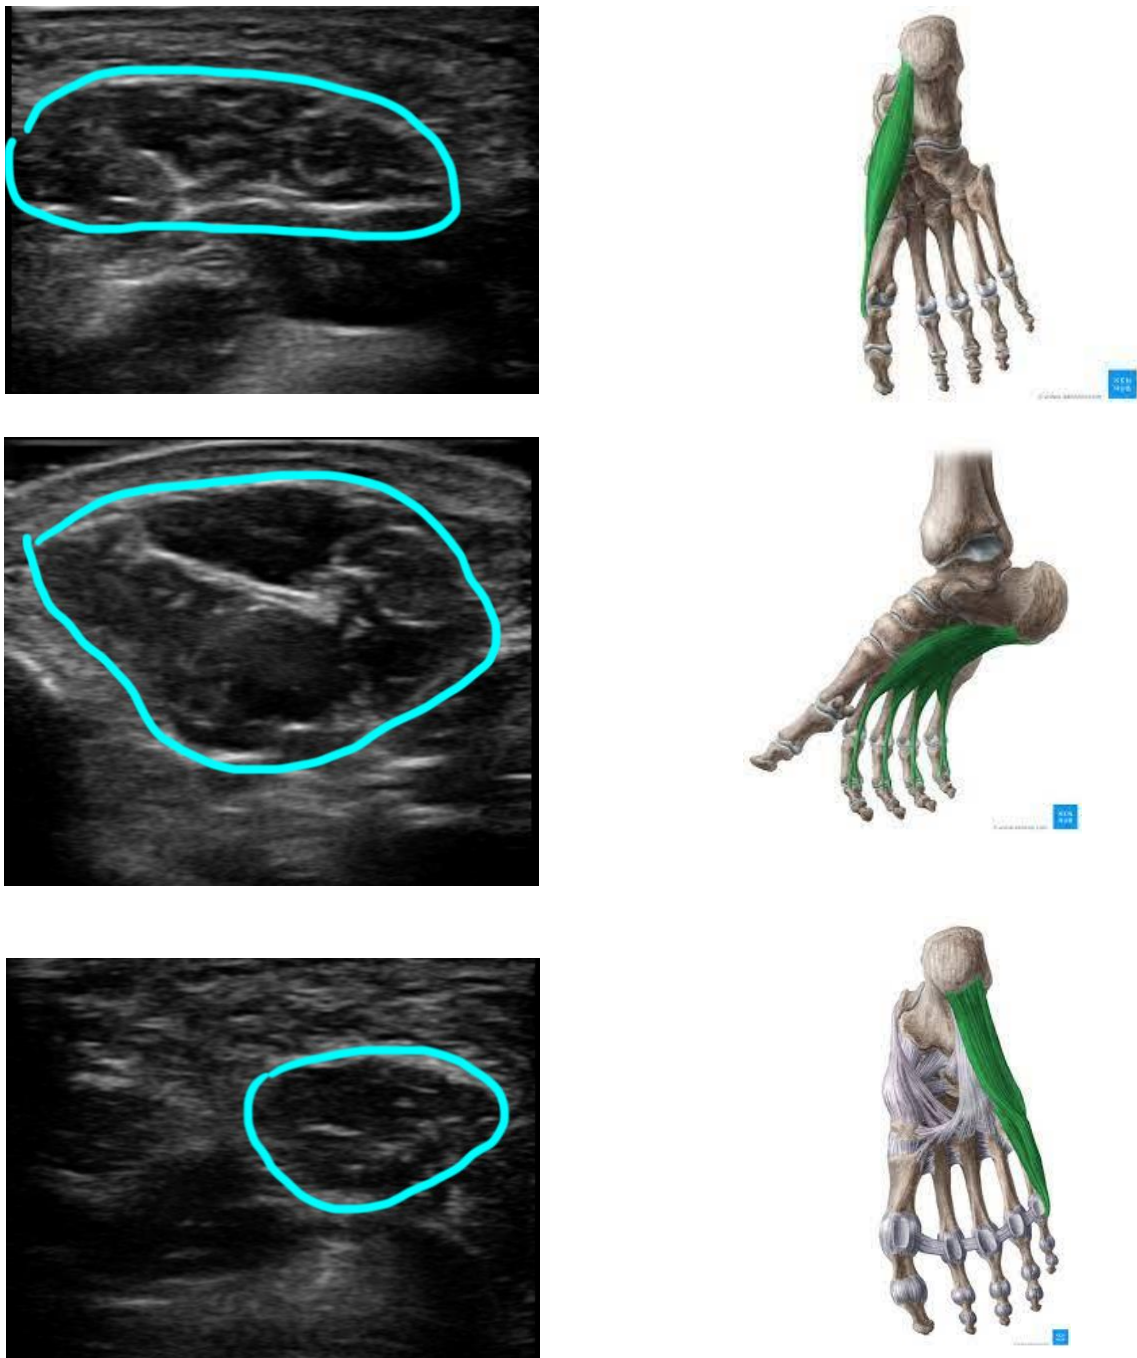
Examples of cross-sectional areas of intrinsic foot muscles captured by ultrasound.
